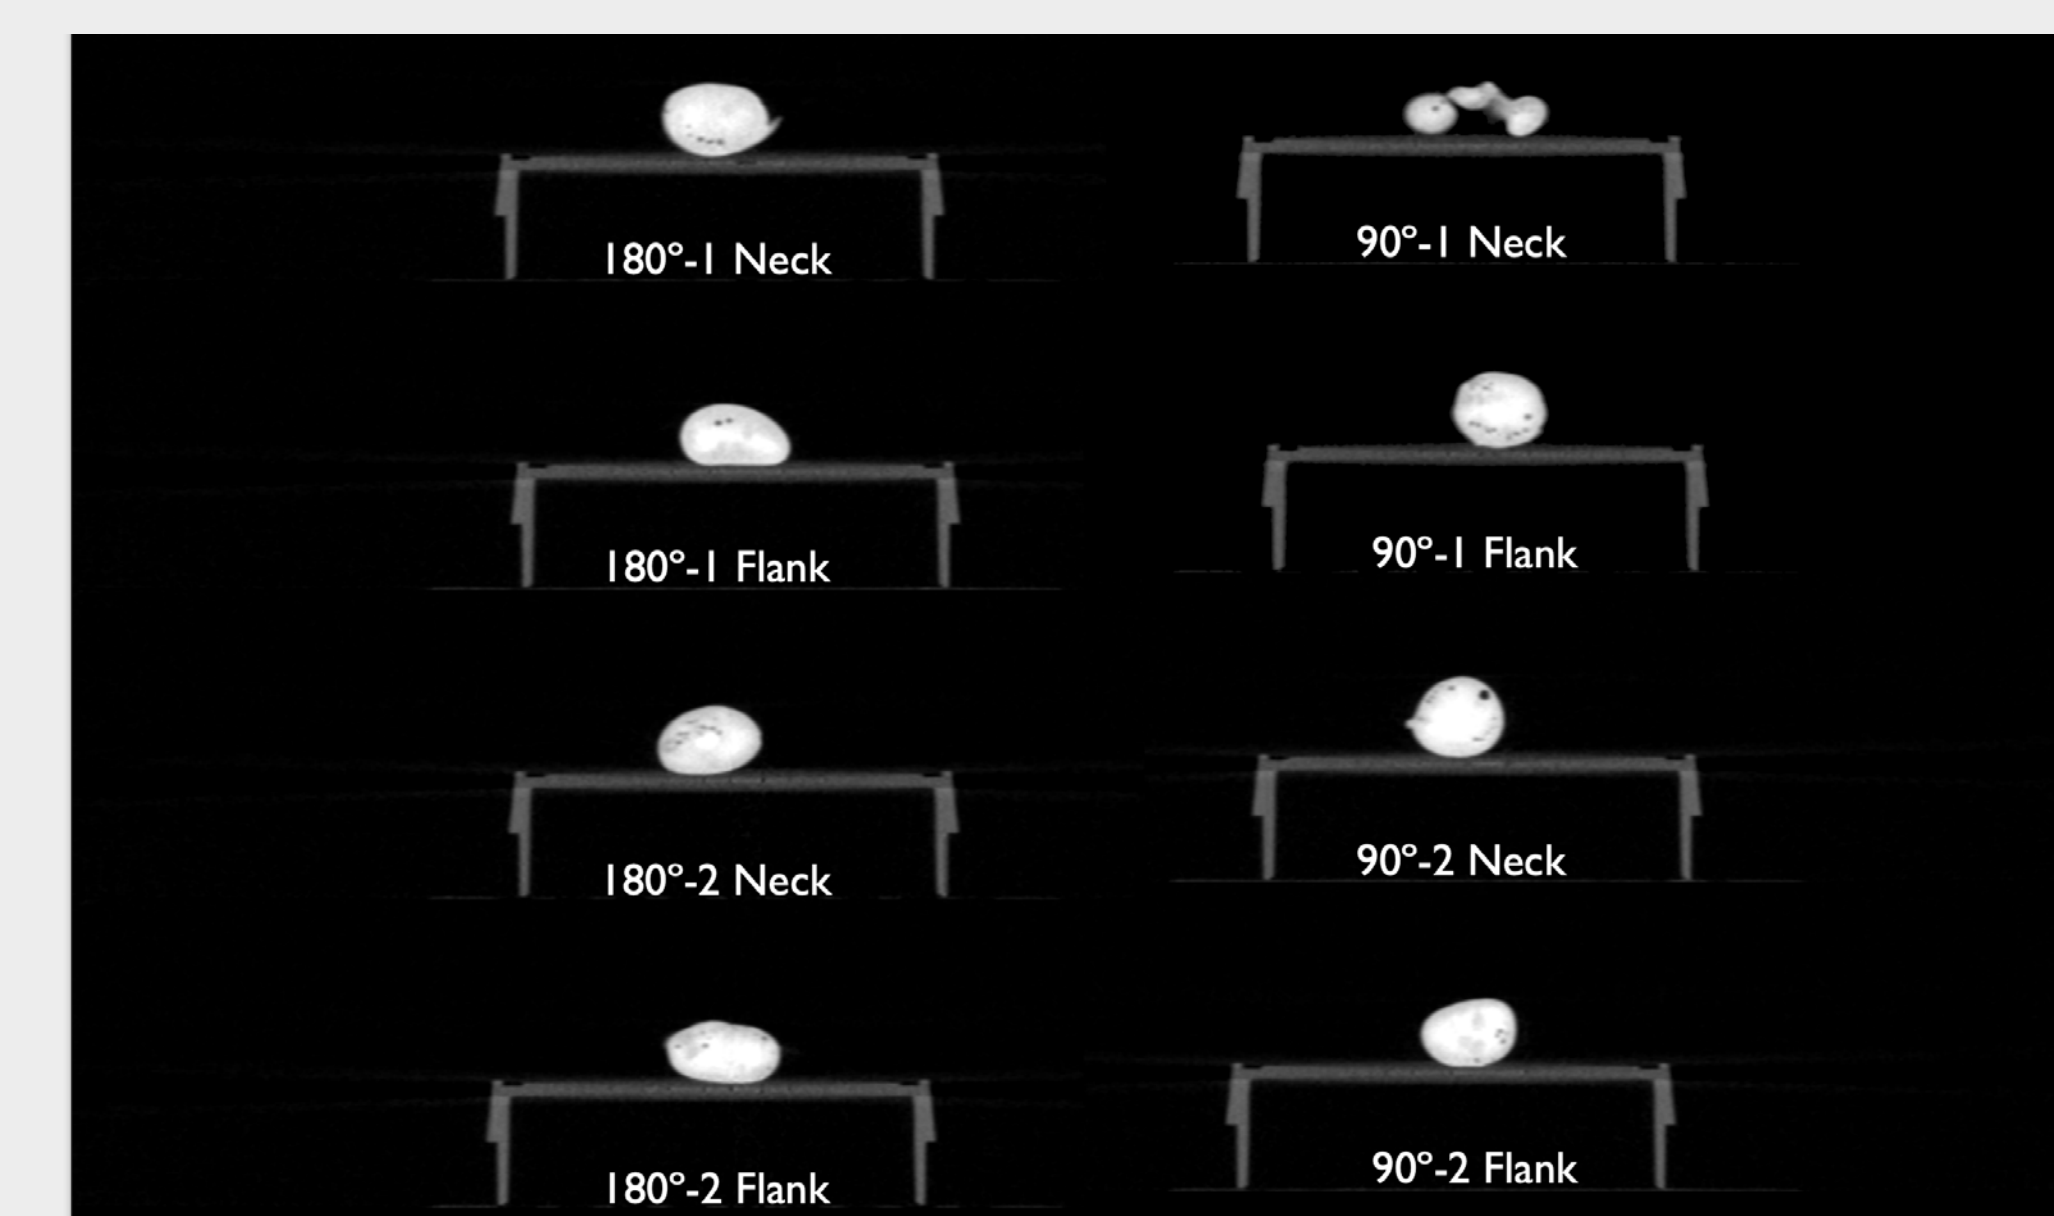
Ex vivo* CT images of *in situ* forming implants formed *in vivo* for 3 hours
